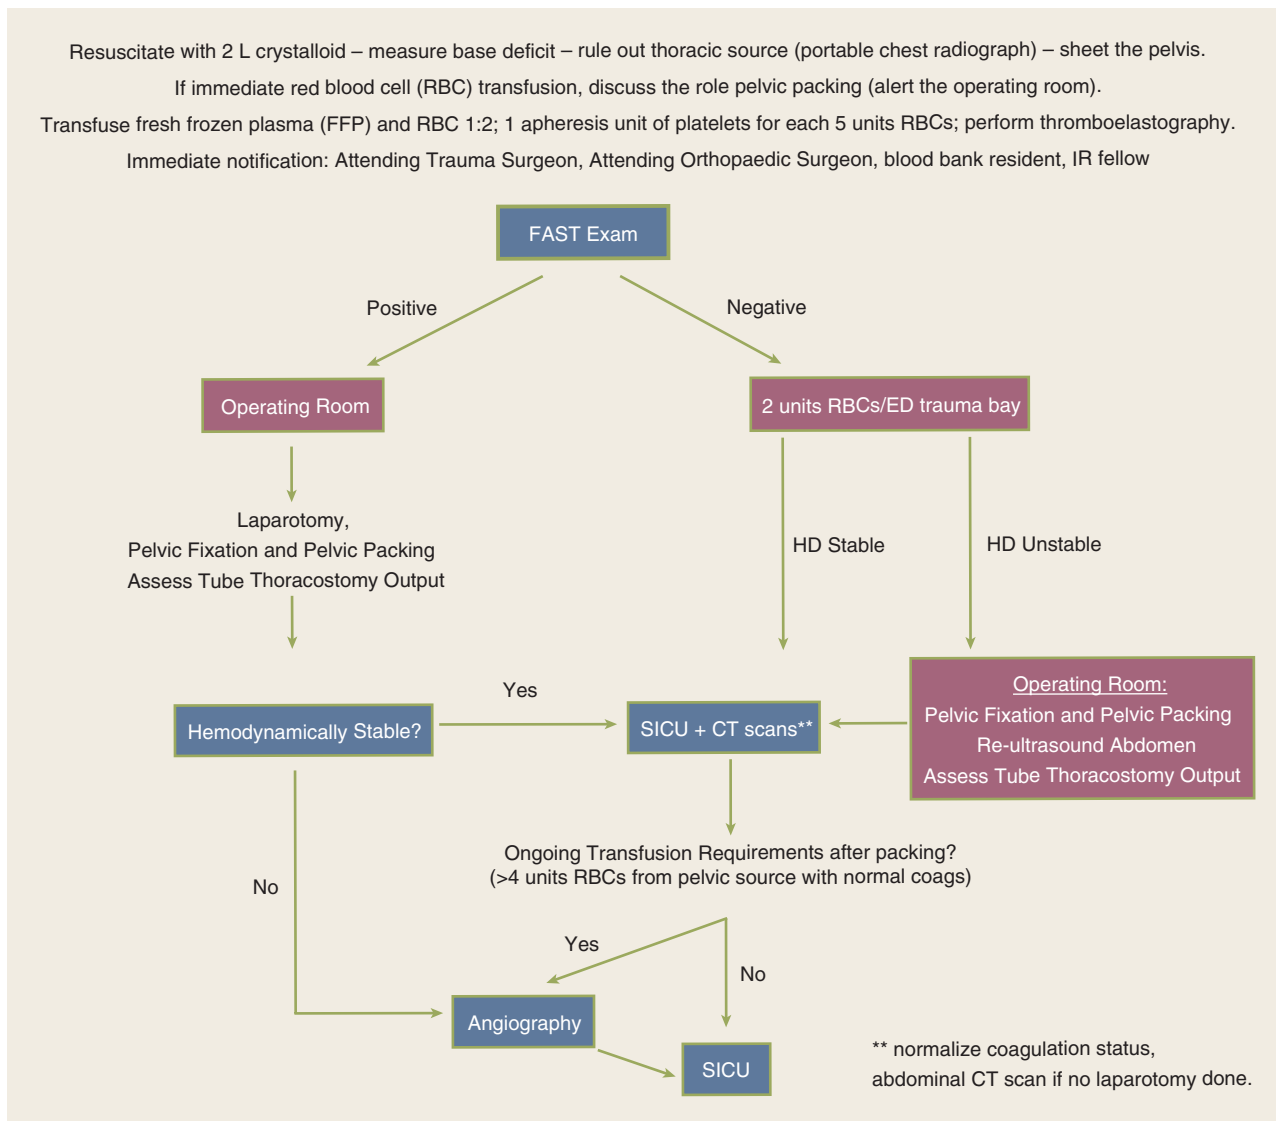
Management algorithm for patients with pelvic fractures with hemodynamic instability. CT = computed tomography; ED = emergency department; FAST = focused abdominal sonography for trauma; HD = hemodynamic; PLT = platelets; PRBCs = packed red blood cells; SICU = surgical intensive care unit.
